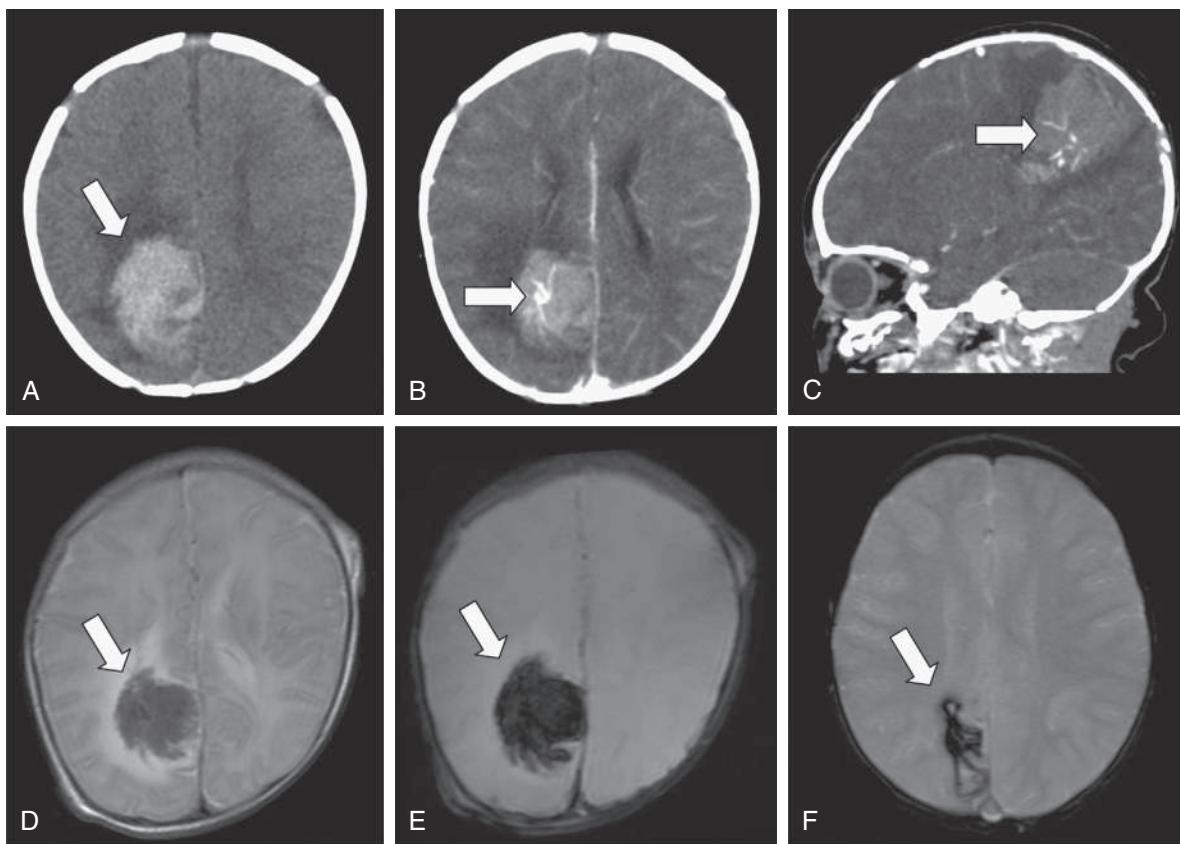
Hemorrhagic stroke. A healthy 1-mo-old presented with sudden-onset irritability followed by focal left body seizures. Plain CT scan of head demonstrates a large hyperdense lesion in the right parietal region with surrounding edema, consistent with acute hemorrhage (A). Axial (B) and sagittal (C) contrast CT scans suggest an abnormal cluster of vessels in the center of the hemorrhage, consistent with an arteriovenous malformation. T2-weighted MRI differentiates the acute hemorrhage from surrounding edema (D). Gradient echo MRI, both acutely (E) and at 3 mo (F), demonstrates the presence of blood product.
